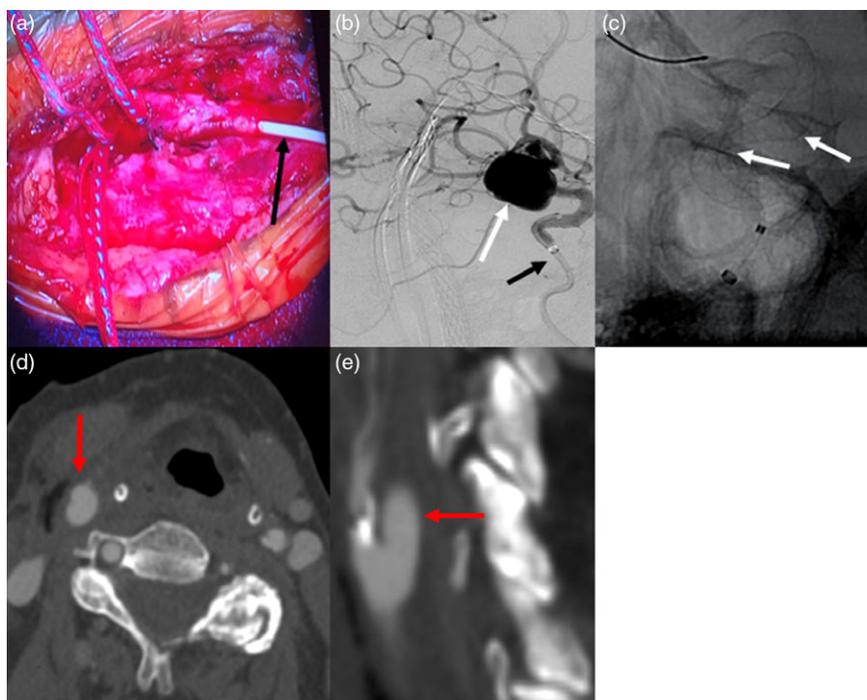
(A) Intraoperative image after the endarterectomy closure demonstrating the vascular sheath inserted into the right internal carotid artery (black arrow), (B) cerebral angiogram through the guide catheter (black arrow) demonstrating the supraclinoid aneurysm (white arrow), (C) unsubtracted image demonstration of the flow diverter device (double white arrows). Day 1 postoperative CTA in axial (D) and sagittal reformat (E) demonstrating widely patent ICA (red arrow).
